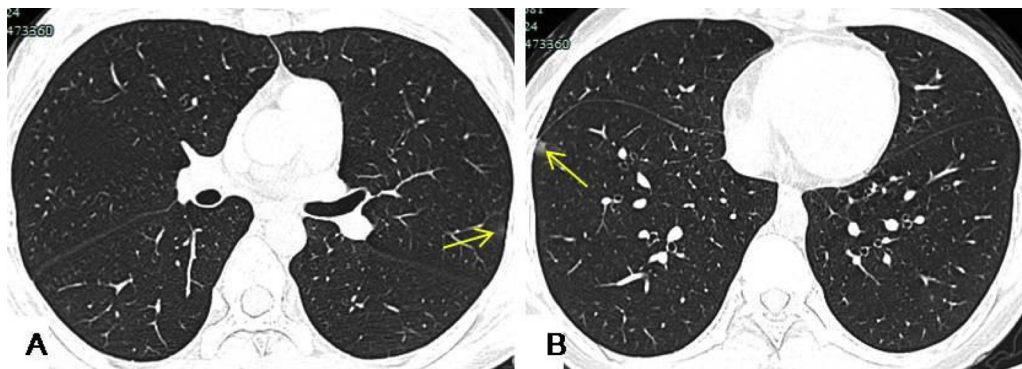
An 11-year-old child was admitted to hospital with a 4-day history of nasal congestion. HRCT showed small patchy opacity approximately 1 cm in diameter in the left upper lobe and in the right lower lobe abutting the pleura. The left upper lobe lesions were thin GGO (A, yellow arrow), and the right lower lobe lesions were mixed GGO (B, yellow arrow).
